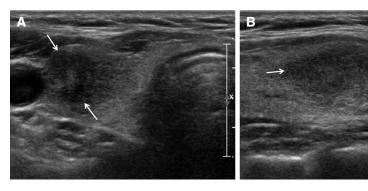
Transverse (A) and longitudinal (B), grey-scale sonograms in a 51-year-old woman, showing a suspicious nodule with marked hypoechogenicity and spiculated margin in the right thyroid (arrows in A and B). This nodular lesion revealed cytologic findings of subacute thyroiditis in ultrasound-guided fine-needle aspiration, and it was finally diagnosed as subacute thyroiditis with a nodular configuration.
